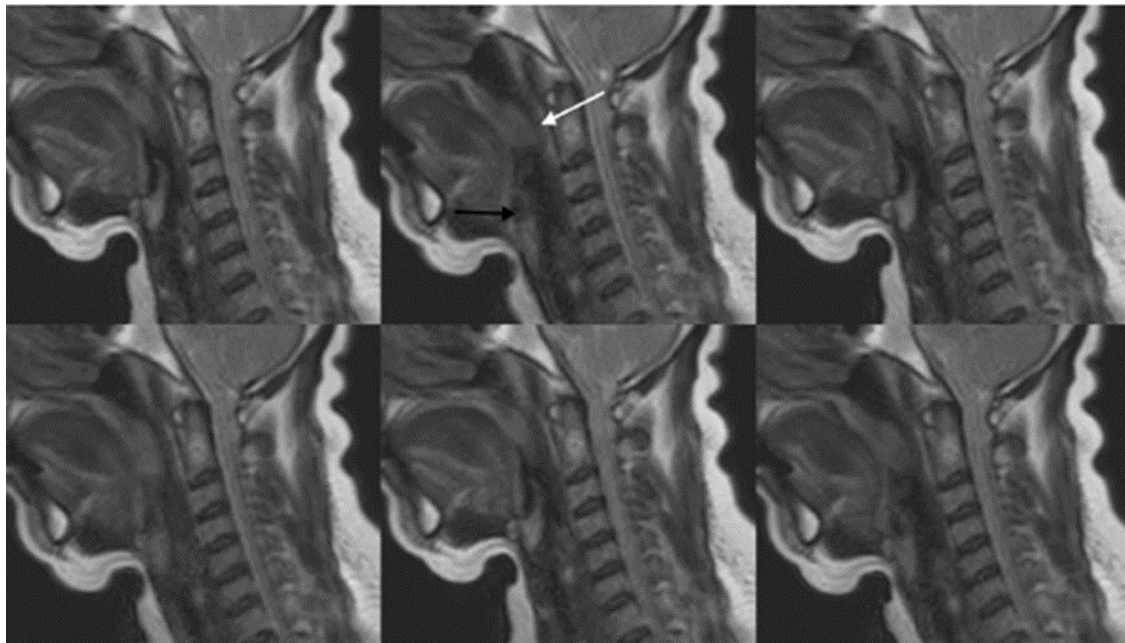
Dynamic sagittal sleep MRI showing patent retroglossal airway (black arrow) and retropalatal airway collapse (white arrow) [2].
